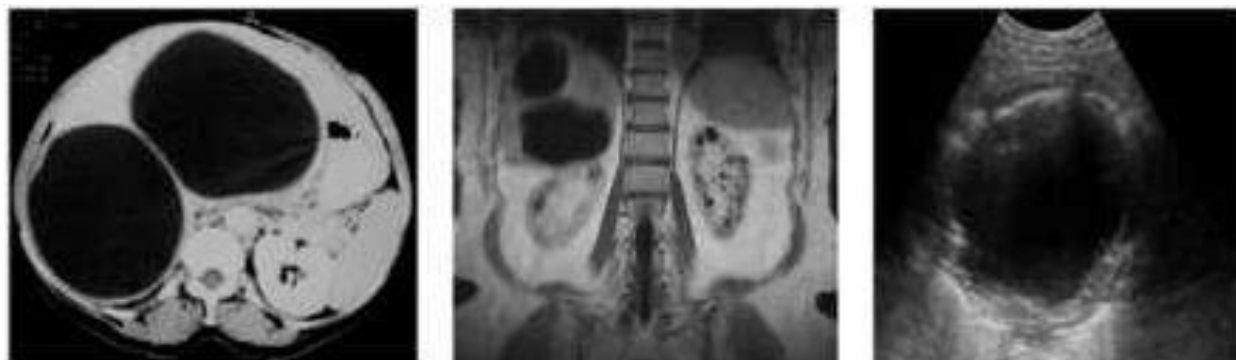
7. E of the liver a) ultrasound - cystic formation with a multilayer capsule, echogenic suspension, marginal weakening of ultrasound b, c) RCT, MRI - cystic formations, thick capsule.
